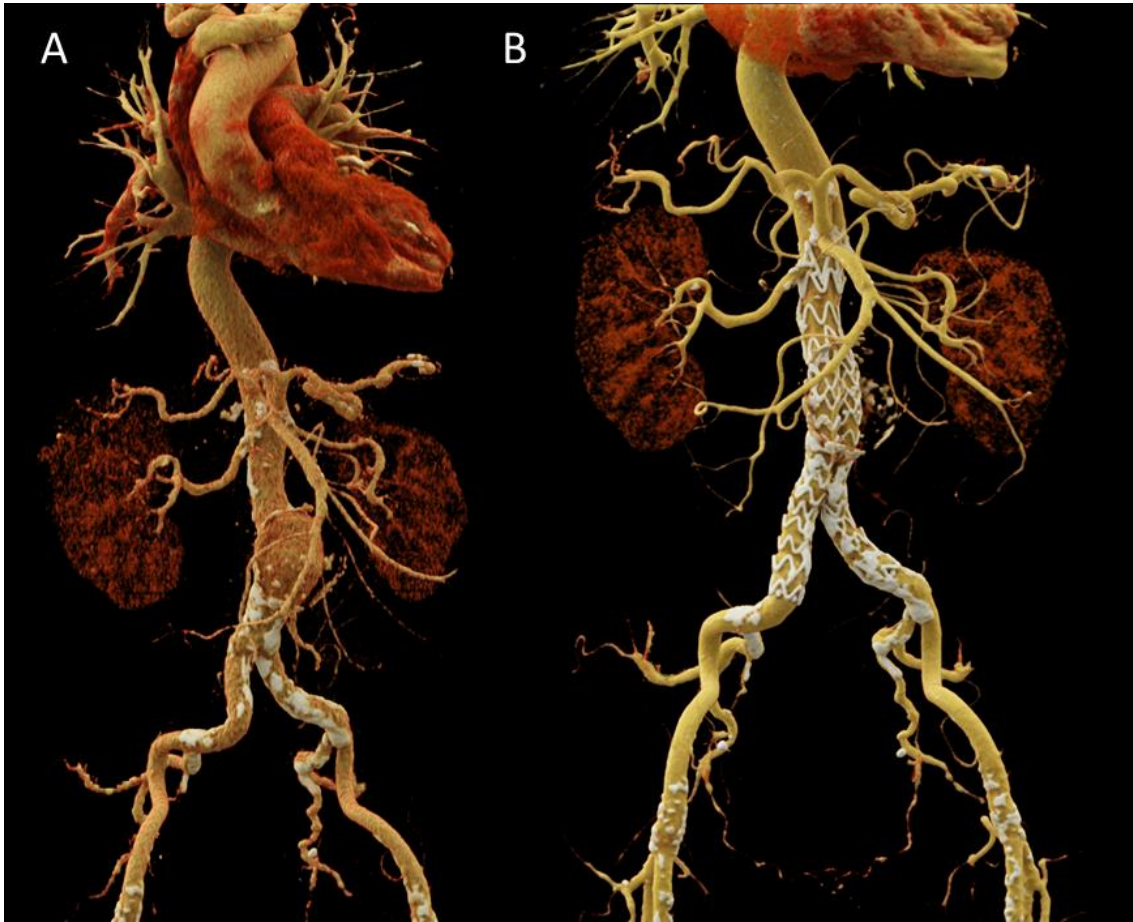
Abdominal aortic aneurysm treated with a Terumo Treo graft (A: preoperative CT scan, B: post EVAR CT scan) (The image was made by Andras Szentivanyi)
